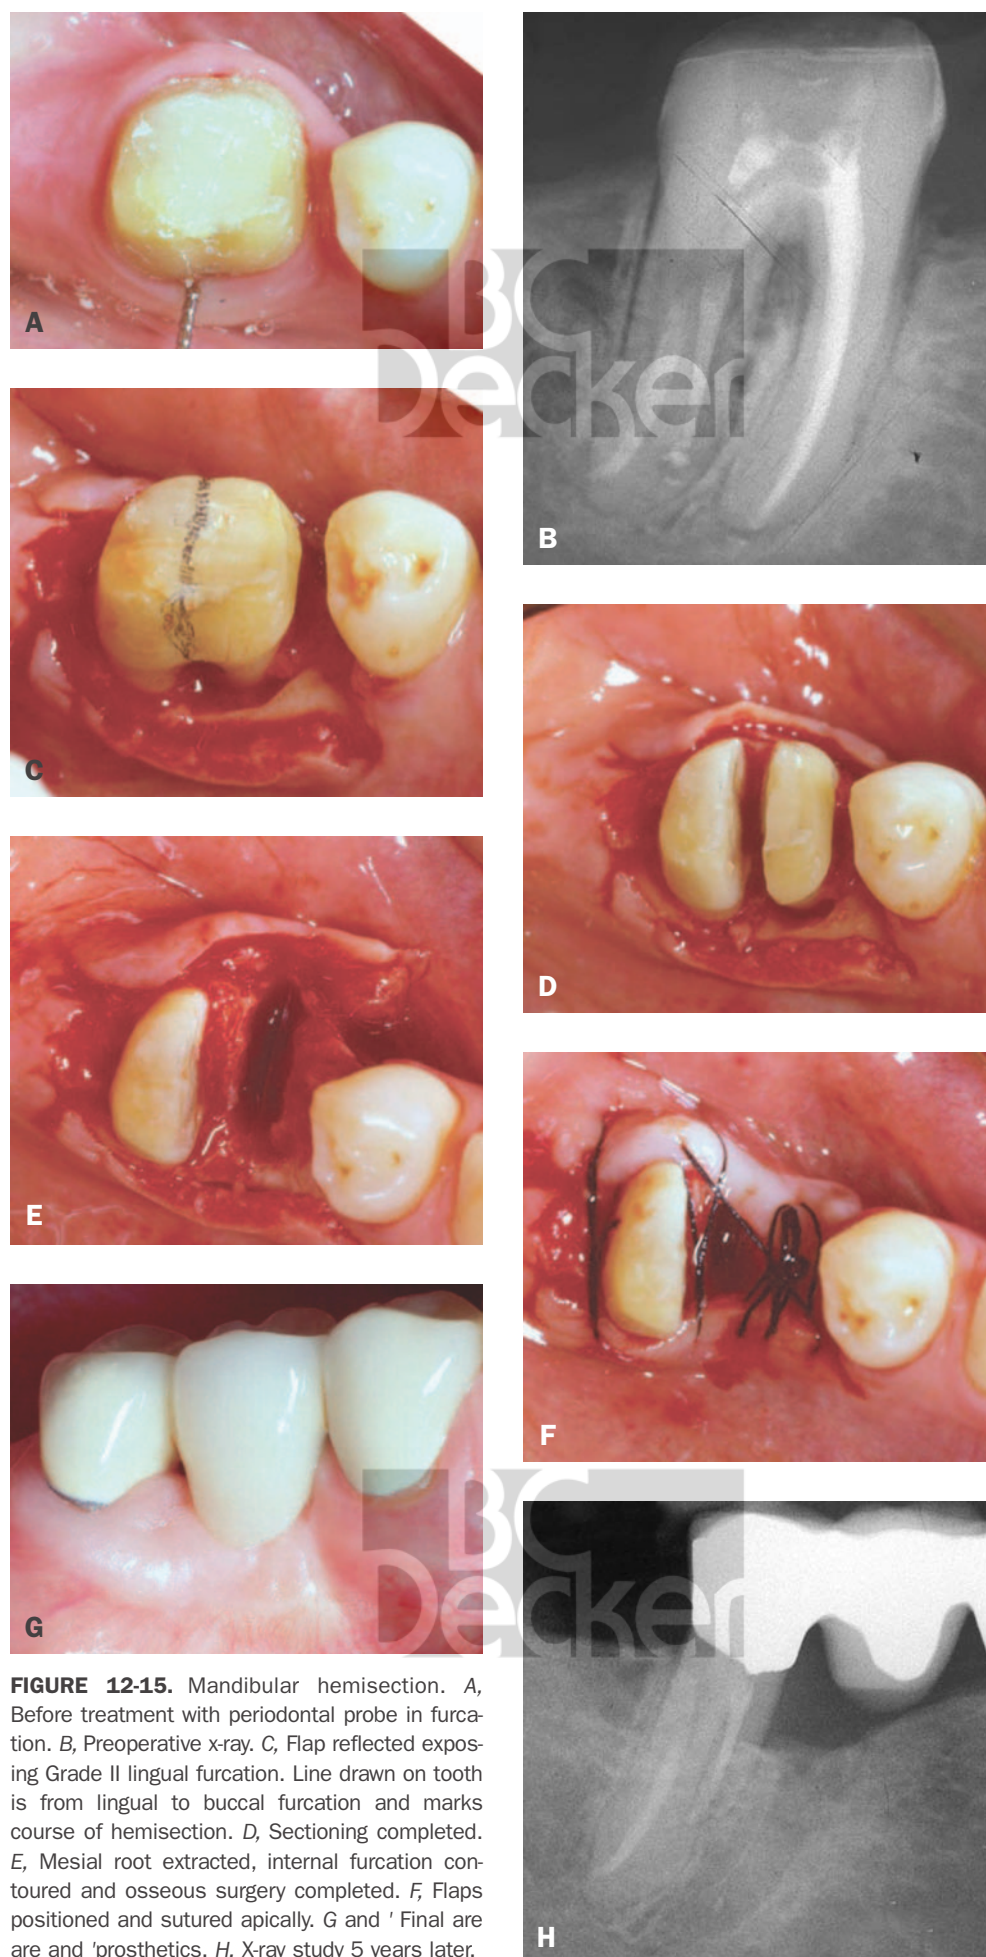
Mandibular hemisection. A, Before treatment with periodontal probe in furcation. B, Preoperative x-ray. C, Flap reflected exposing Grade II lingual furcation. Line drawn on tooth is from lingual to buccal furcation and marks course of hemisection. D, Sectioning completed. E, Mesial root extracted, internal furcation contoured and osseous surgery completed. F, Flaps positioned and sutured apically. G and H, Final are and 'prosthetics. H, X-ray study 5 years later.
